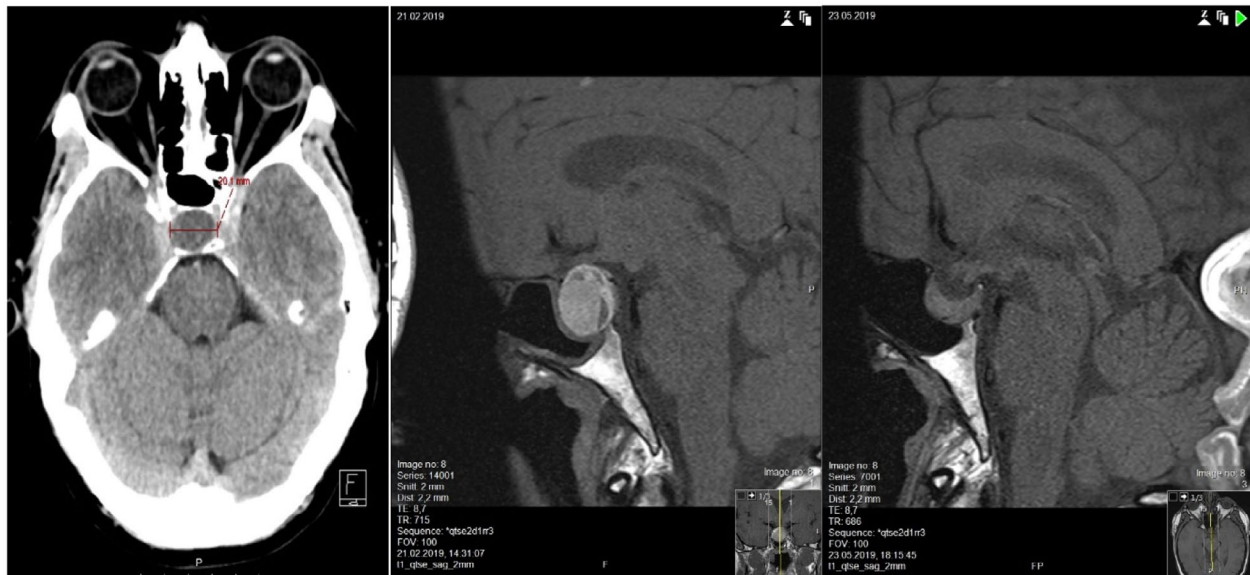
Pituitary apoplexy. Picture on the left shows an expanding mass within sella turcica on CT performed 7 hours after sudden-onset severe headache. Post contrast T1-weighted MRI (picture in the middle) shows a solid hyperintense tumor with rim enhancement and with a low signal fluid-level. Findings are compatible with a hemorrhagic apoplexy in a macroadenoma. T1-weighted MRI on the right shows regression of the tumor and no signs of bleeding three months after the event. Notice the mucosal thickening in the sphenoid sinus mucosa (picture in the middle), which probably relates to venous congestion, that later resolved (right picture). [Color figure can be viewed at wileyonlinelibrary.com]
